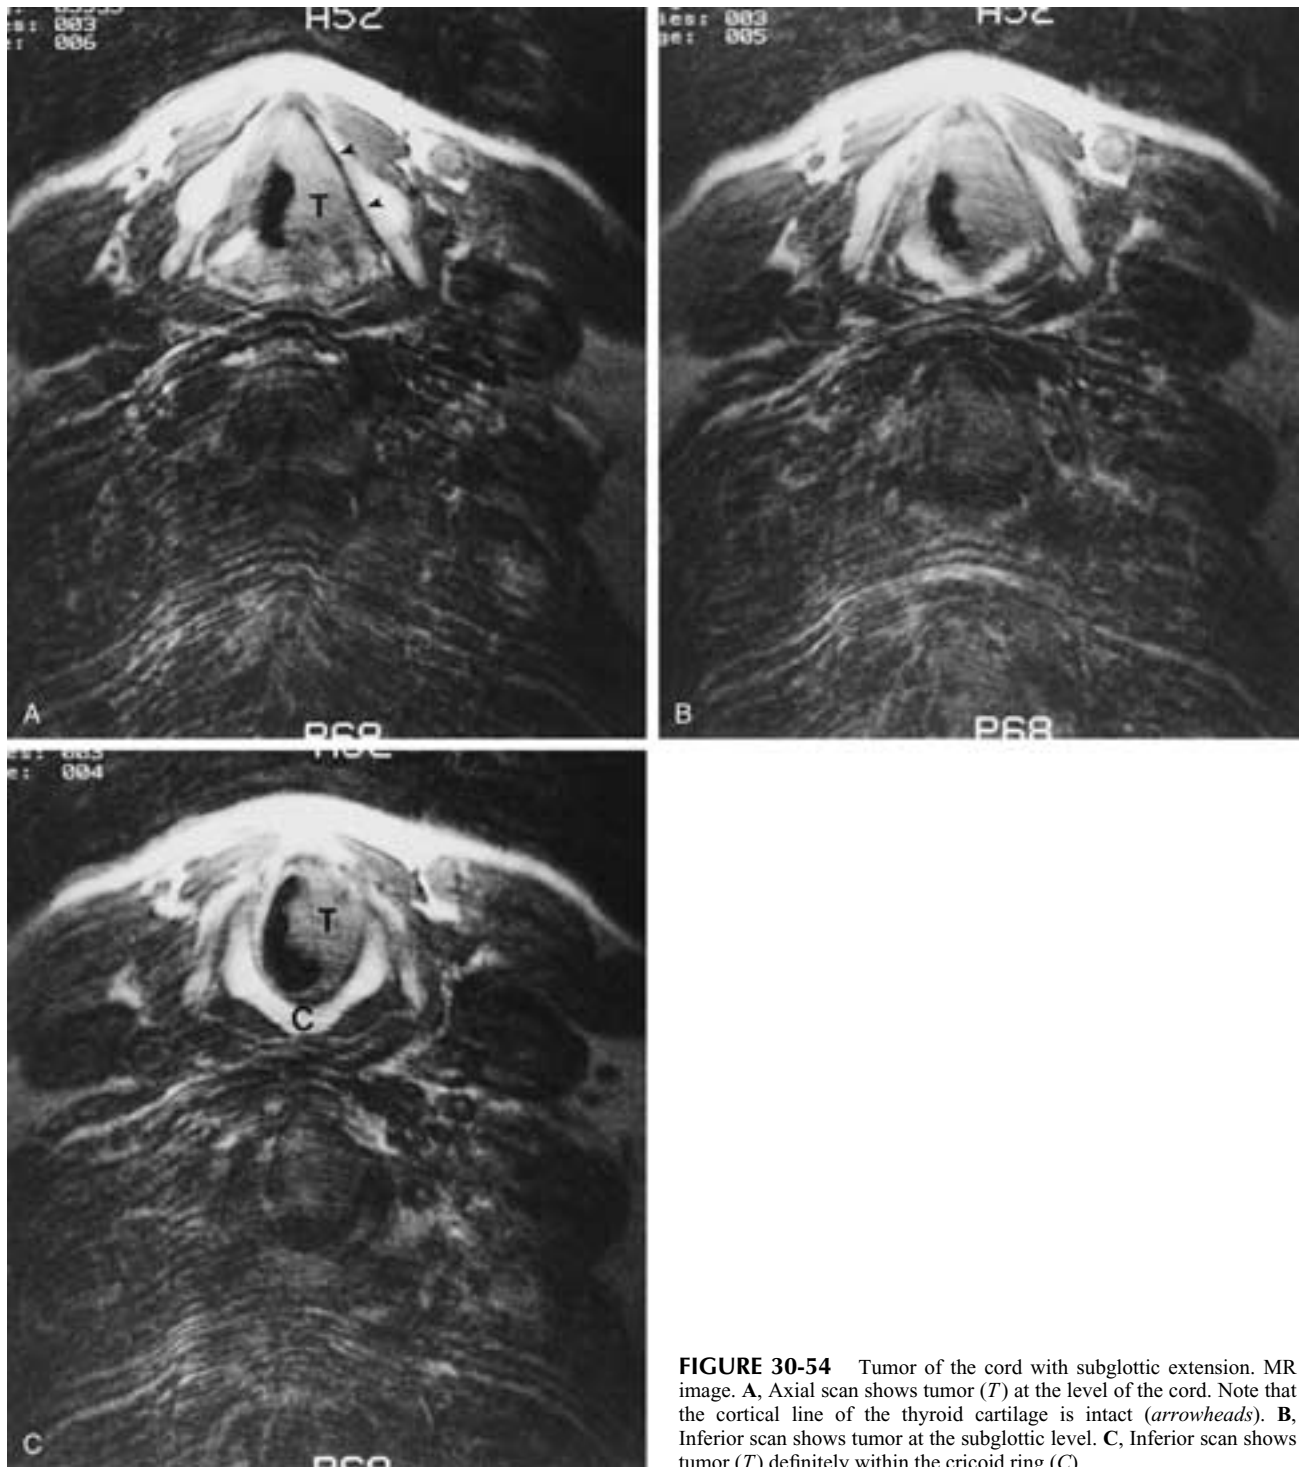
Tumor of the cord with subglottic extension. MR image. A, Axial scan shows tumor (*T*) at the level of the cord. Note that the cortical line of the thyroid cartilage is intact (*arrowheads*). B, Inferior scan shows tumor at the subglottic level. C, Inferior scan shows tumor (*T*) definitely within the cricoid ring (*C*).
